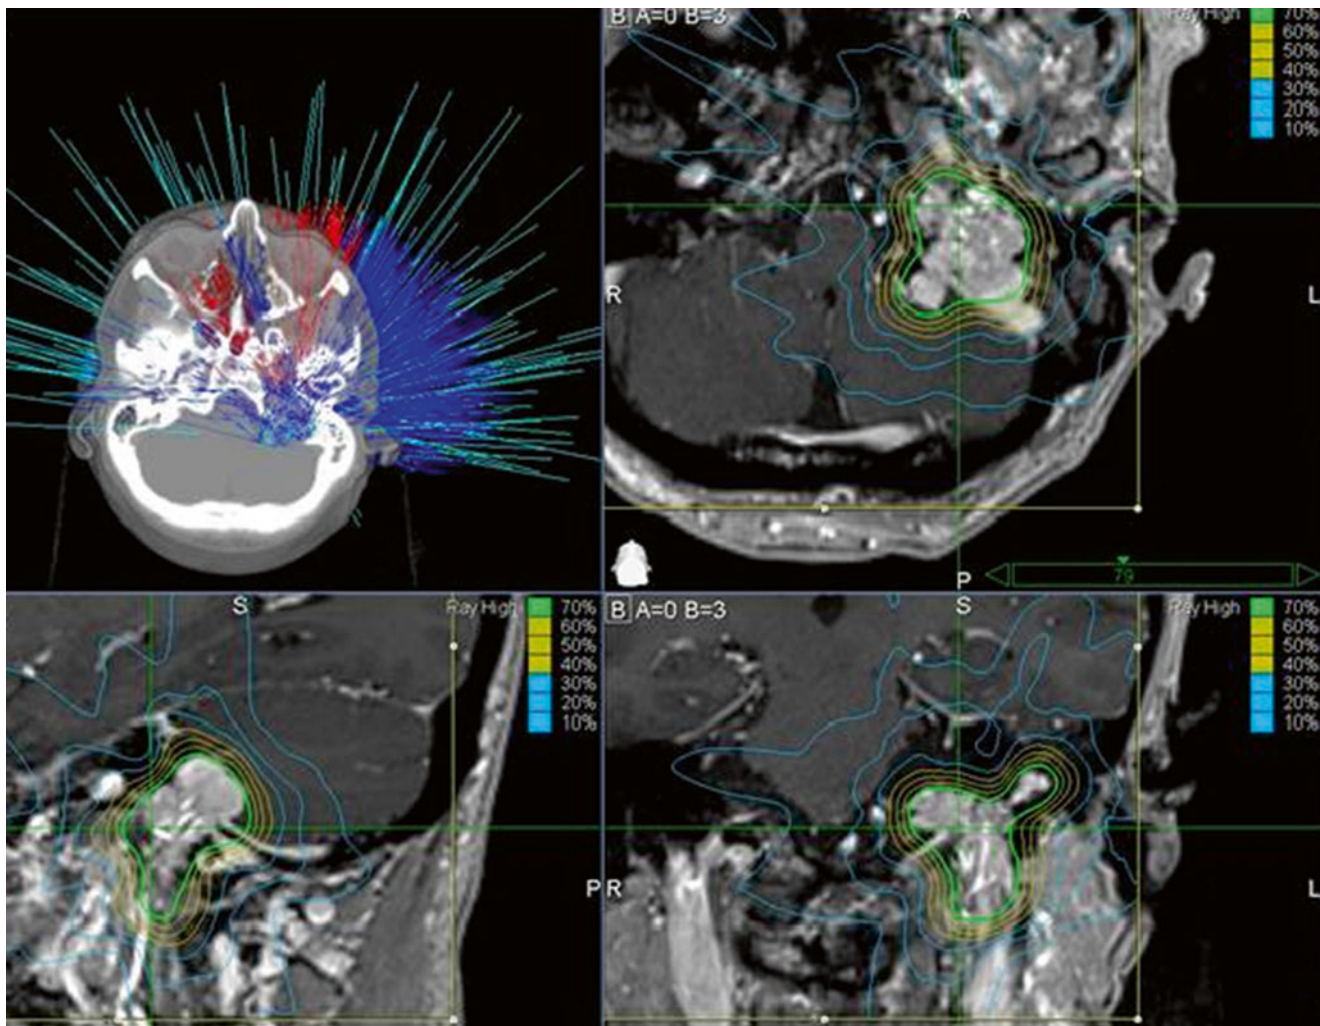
Treatment plan of a patient presenting with hearing deficit, vertigo and vocal cord paresis. MR imaging showed a left sided glomus tumor treated radiosurgically with 17 Gy marginal dose (70 % isodose). After 24 months the tumor has shrunk, no new toxicity (courtesy of Dr. A. Muacevic, CyberKnife Centre Munich)
